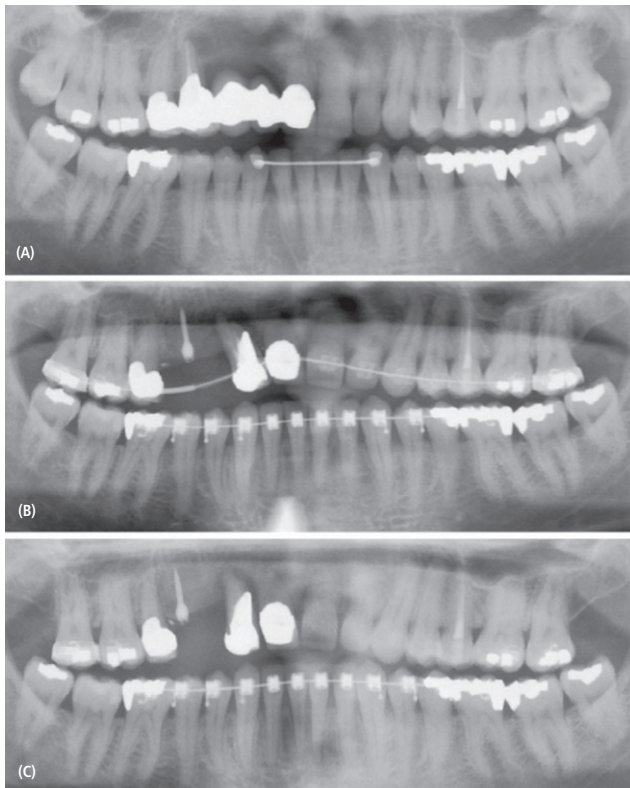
Panoramic radiographs. A. Pretreatment. B. Progress with temporary anchorage device (TAD). C. Implant site preparation completed prior to extrusion and extraction of maxillary right first premolar and implant placement.
